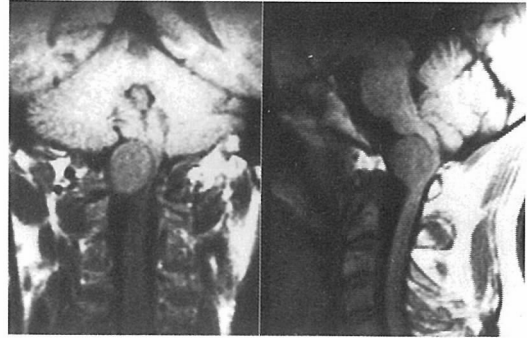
Coronal (left) and sagittal (right) MRI (case 1). A well demarcated round mass in the foramen magnum compresses the medulla and the upper spinal cord.
